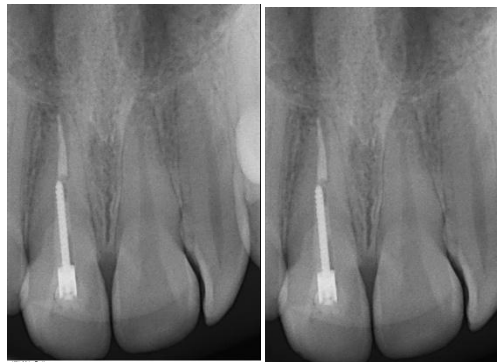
Follow up radiograph at 6 and 12 months
